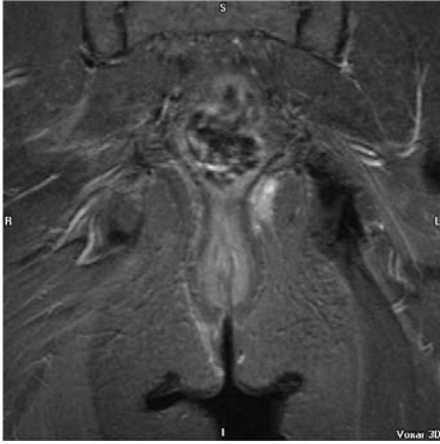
Coronal T2-weighted image with fat saturation. Trans-sphincteric fistula with inflammatory change in the left ischioanal fossa
